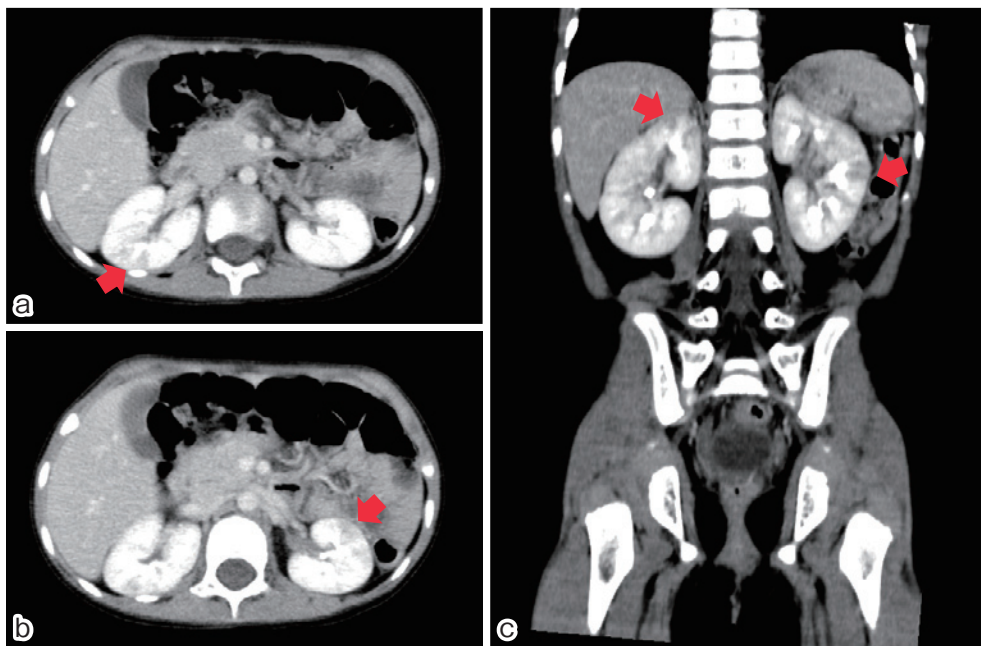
AFBN in both kidneys noted on abdominal enhanced contrast CT (mark by arrow): a) b) on transverse plane, c) on coronal plane.
